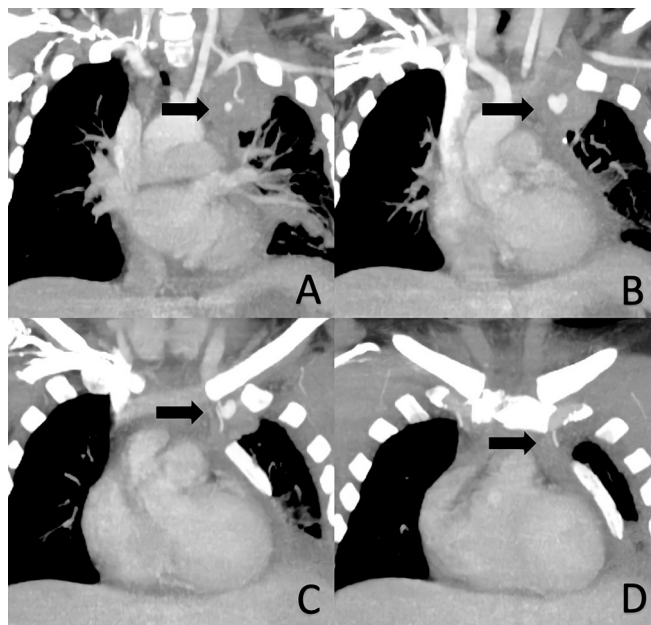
Enhanced sagittal CT scan images. Enhanced left infraclavicular pseudoaneurysm of internal thoracic artery is identified (arrows).
